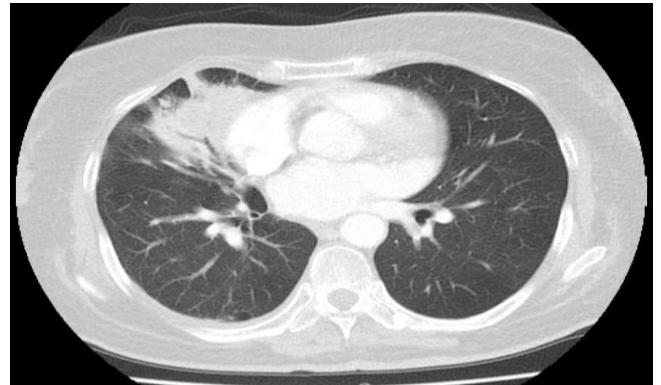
Thoracic CT on admission showing right Pneumonic consolidation
